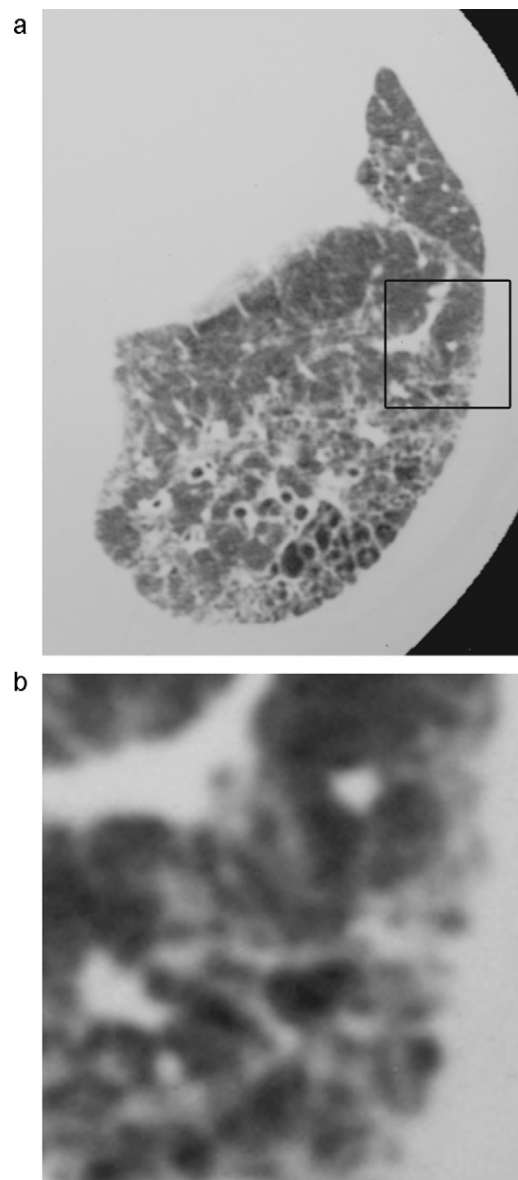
(a) Transverse thin-section CT image of left lower lung in a 56-year-old man with radiological and pathological UIP shows peripheral ground-glass opacity, reticular opacity and honeycombing. (b) Extracted image from left segment 8 in the biopsy site shows ground-glass opacity, reticular opacity and microcysts. The impression of images is heterogeneous. This site was diagnosed as UIP pattern by radiologists and pathologists.
